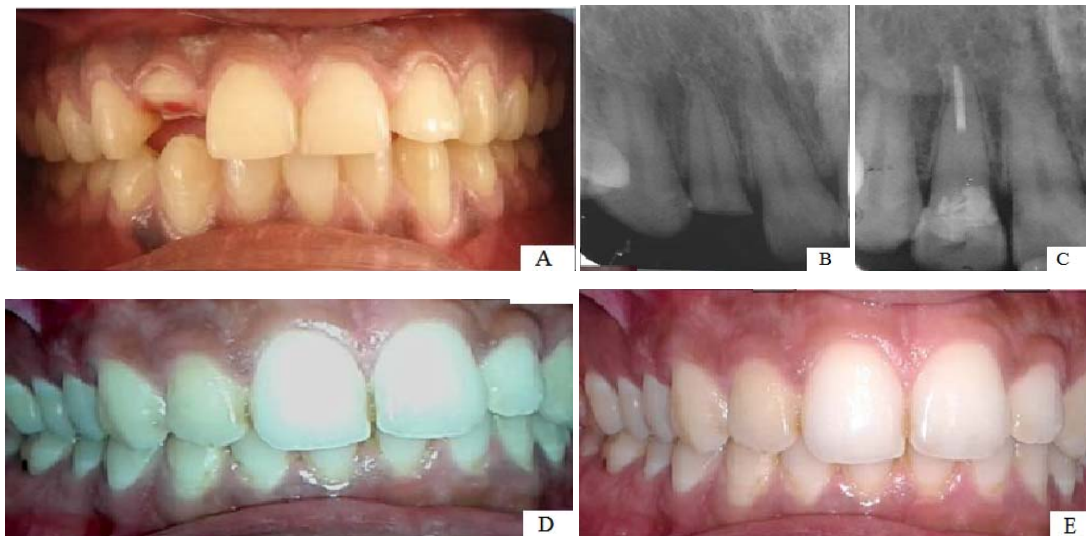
(A) Pre-operative view; (B) Fractured fragment - Lingual view; (C) Intraoral periapical radiograph showing reattached fragment; (D) Post-operative view; (E) 1 year follow up
